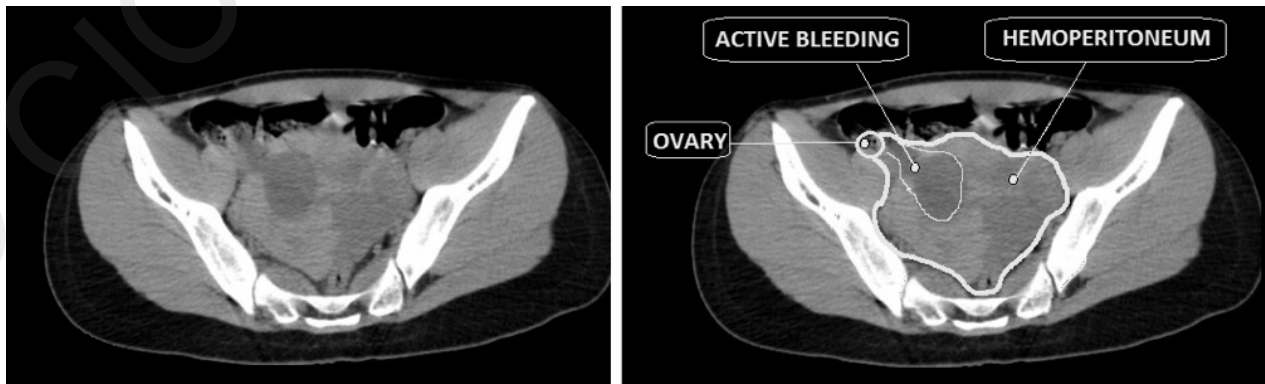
Abdominal CT scan that shows a hyperdense spot on the right adnexal compatible with active bleeding.
